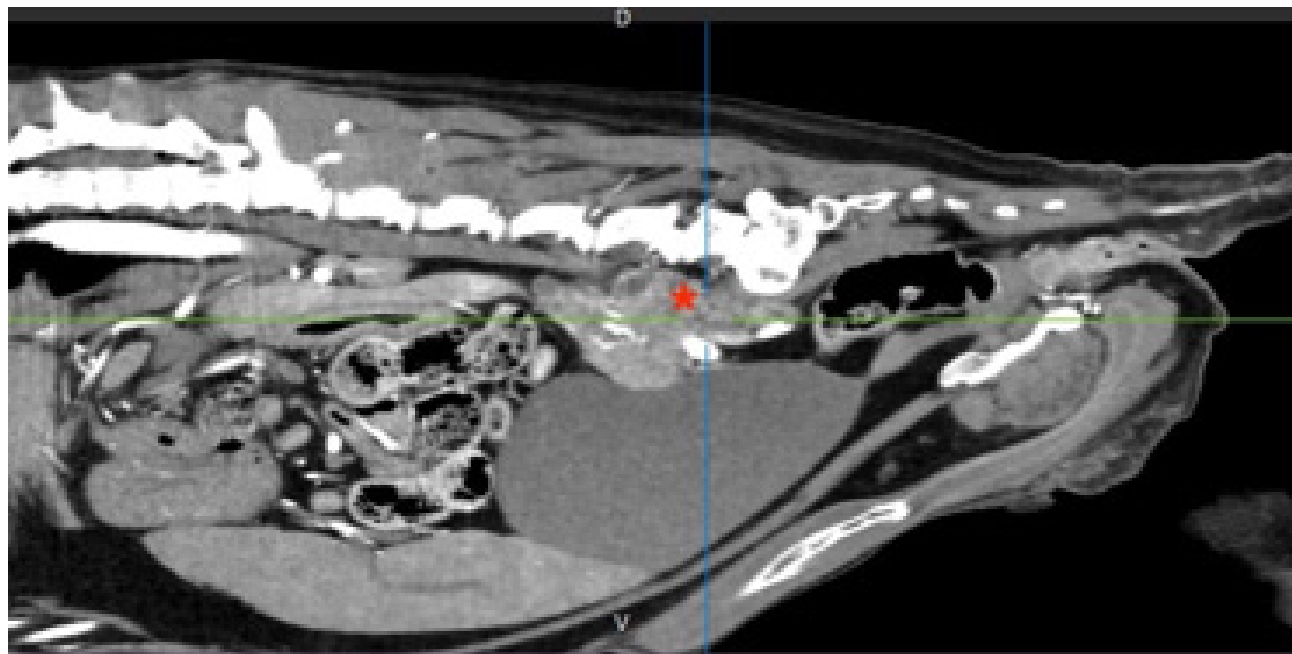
Sagittal computed tomography projection demonstrating a heterogeneous, contrast-enhancing, lobulated metastatic sub-lumbar lymph node (red star)
